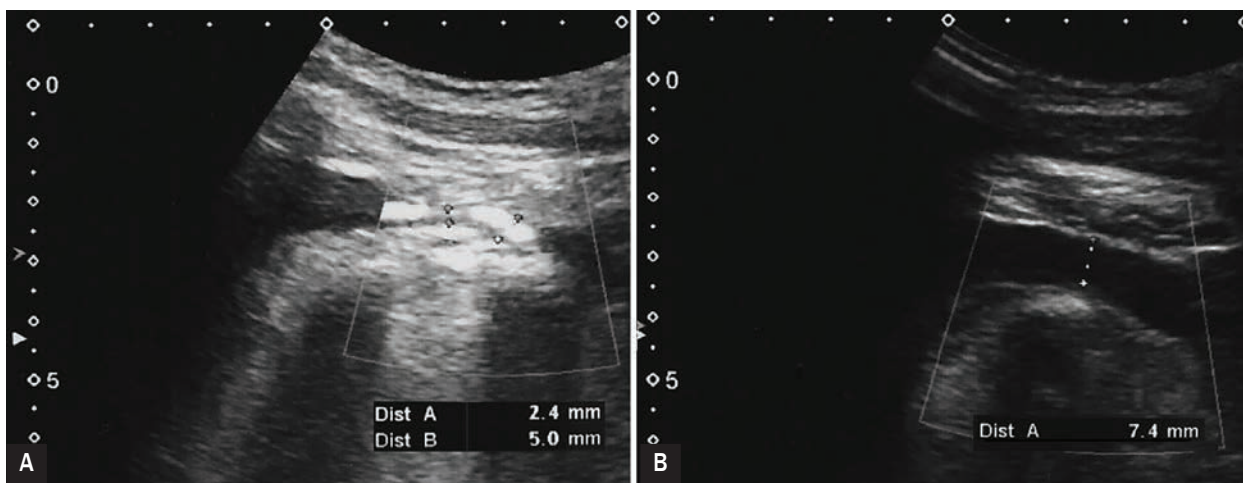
Ultrasound images: A. The patient in a horizontal position with the left upper limb lying along the torso – subclavian vein (SV) compression in its middle segment to a minimum diameter of 2–5–3 mm, depending on the respiratory phase; B. During the Valsalva manoeuvre (inspiration), the SV diameter increases to 7 mm
